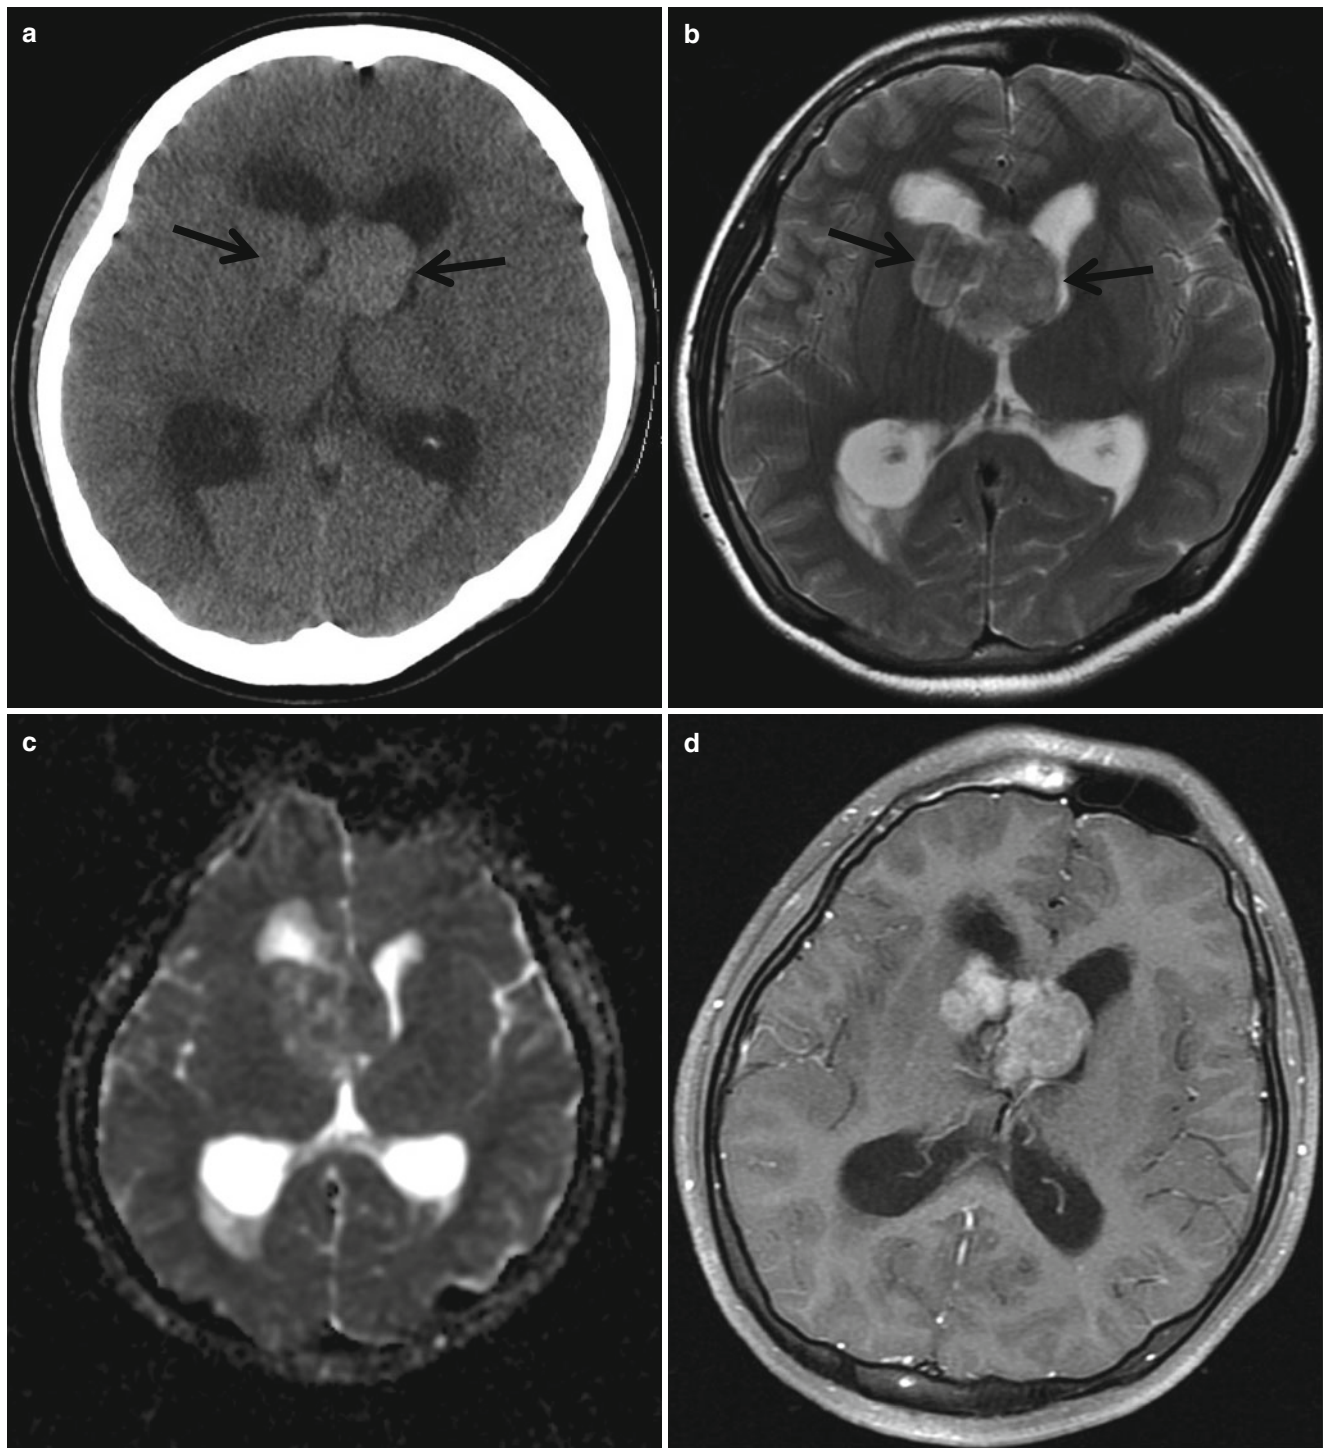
Atypical teratoid/rhabdoid tumor (ATRT) in a 14-year-old boy. (a) CT scan shows lobulating high-density mass (*arrows*) at the foramen Monro causing hydrocephalus. (b) The mass (*arrows*) is
